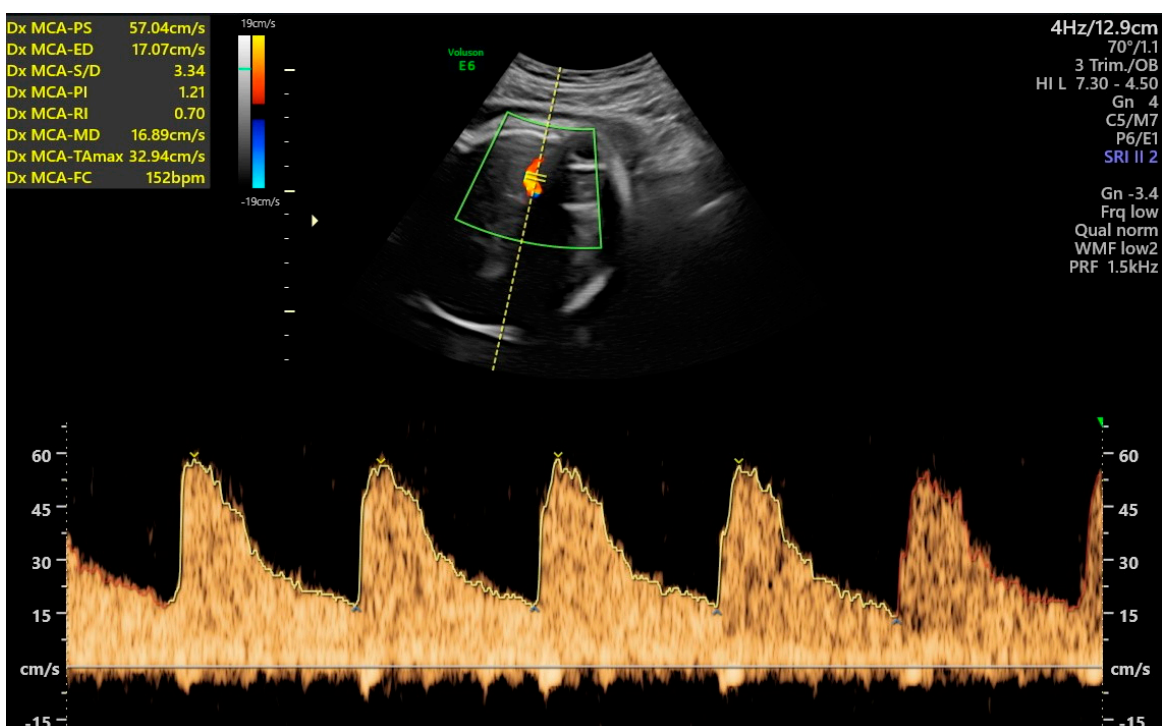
Ultrasound Doppler of the middle cerebral artery pulsatility index at 34 weeks and 6 days.
